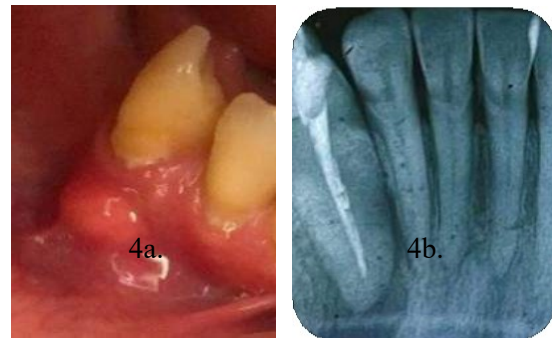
(left). Clinical photograph showing acute periodontal abscess at tooth 43 after 15 months of obturation. Figure 4b (right). Periapical radiograph showing extended radiolucency
